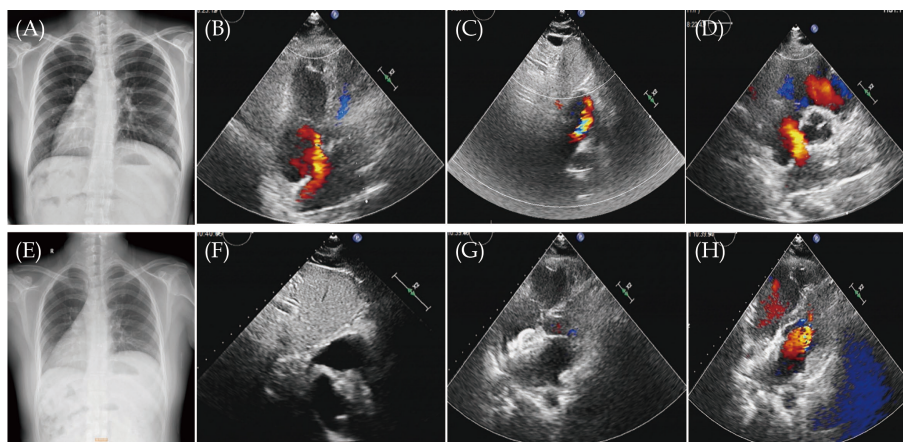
Preoperative and postoperative echocardiography and chest X-ray images. (A): The preoperative chest X-ray; (B–D): the images of the apical four-chamber view, subxiphoid biatrial view, and great artery short-axis view before surgery, showing a secundum atrial septal defect with a 16 mm interruption in the atrial septal echo and good marginal conditions; (E): the postoperative chest X-ray; (F & G): the images of the subxiphoid biatrial view and apical four-chamber view after occluder implantation, showing good positioning of the occluder; and (H): the postoperative apical four-chamber view showing no residual shunt across the atrial septum.
